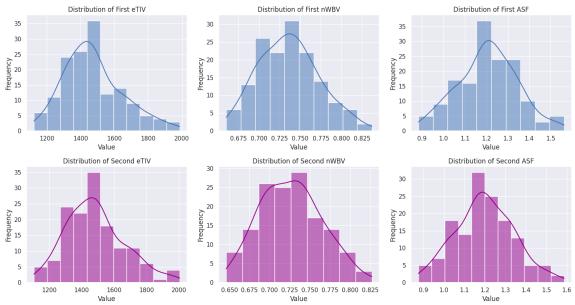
Distribution of MRI tests for brain volume for all subjects during first (top) and second (bottom) visit.
